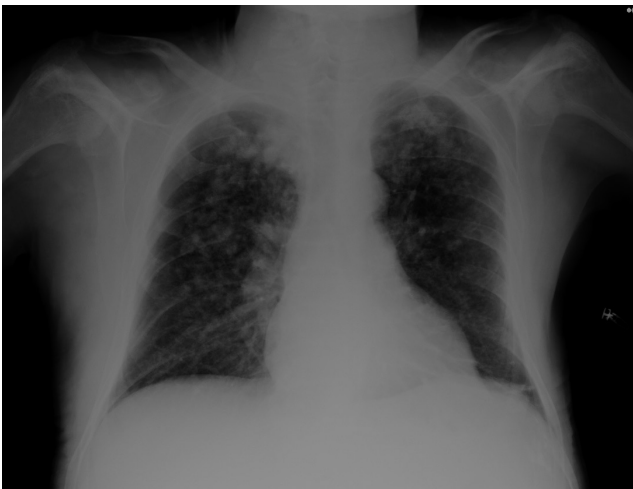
Chest X-ray shows numerous diffuse confluent nodular opacities with poorly defined margins, predominantly in the upper zone
